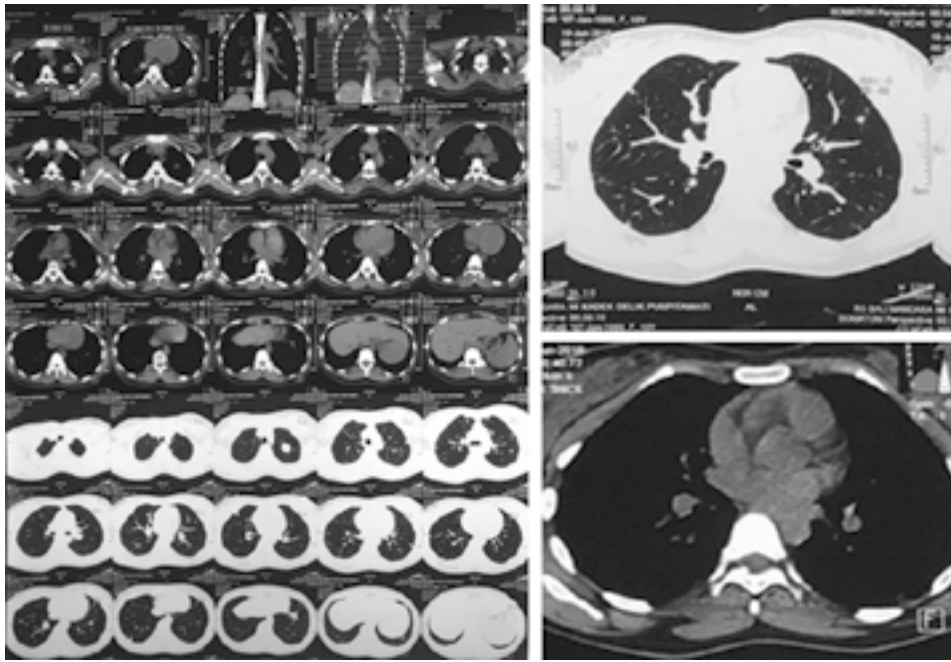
Chest computed tomography scan after 2 years after surgery, showing metastatic nodules at almost all lobes of the lung
